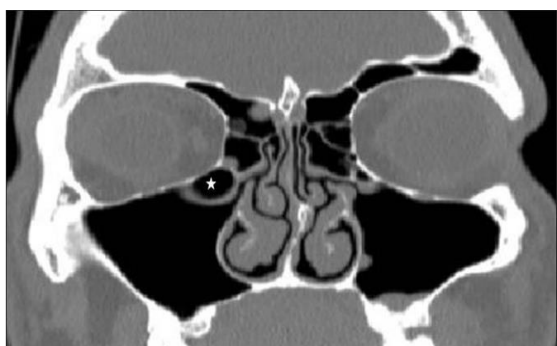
Coronal CT slice at osteomeatal complex level showed Haller cells(*)
